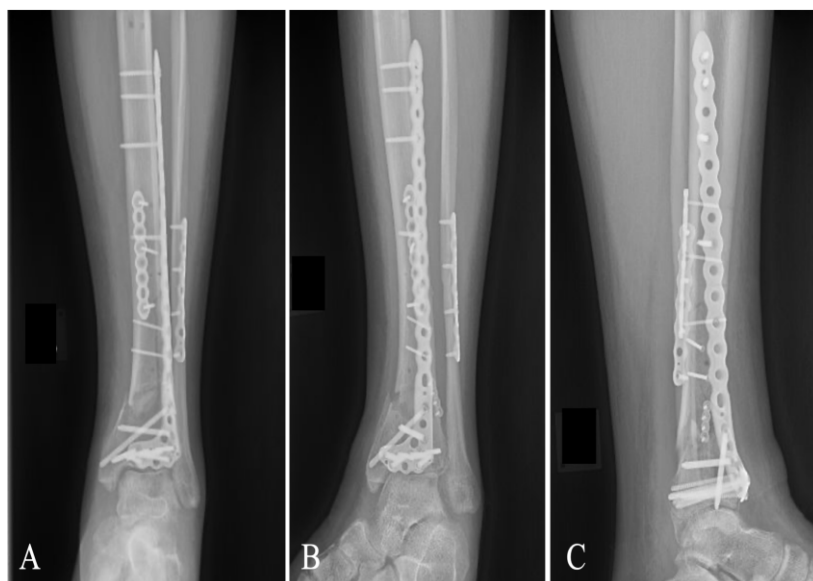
Three month post-operation radiographs of the left ankle including (A) anteroposterior, (B) mortise, and (C) lateral views demonstrating healing of the fibular fracture with minimal healing of the tibial metaphysis despite well-maintained tibial alignment.
